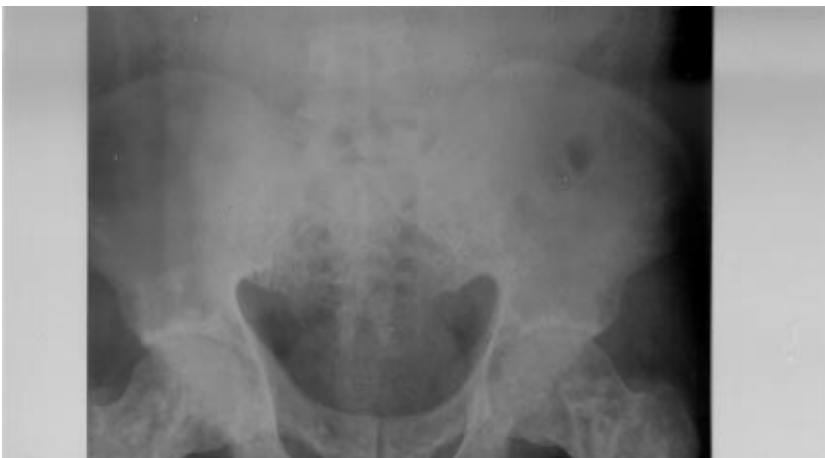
Osteopoikilotic lesions on lumbo-sacral roentgenogram of the patient
